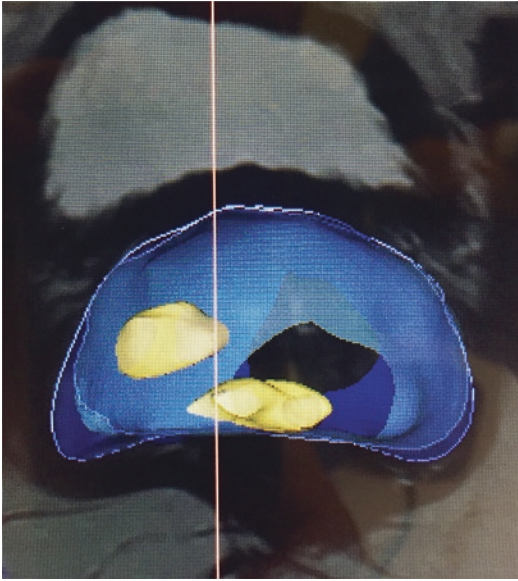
Three-dimensional magnetic resonance imaging-ultrasound (MRI-US) fusion
